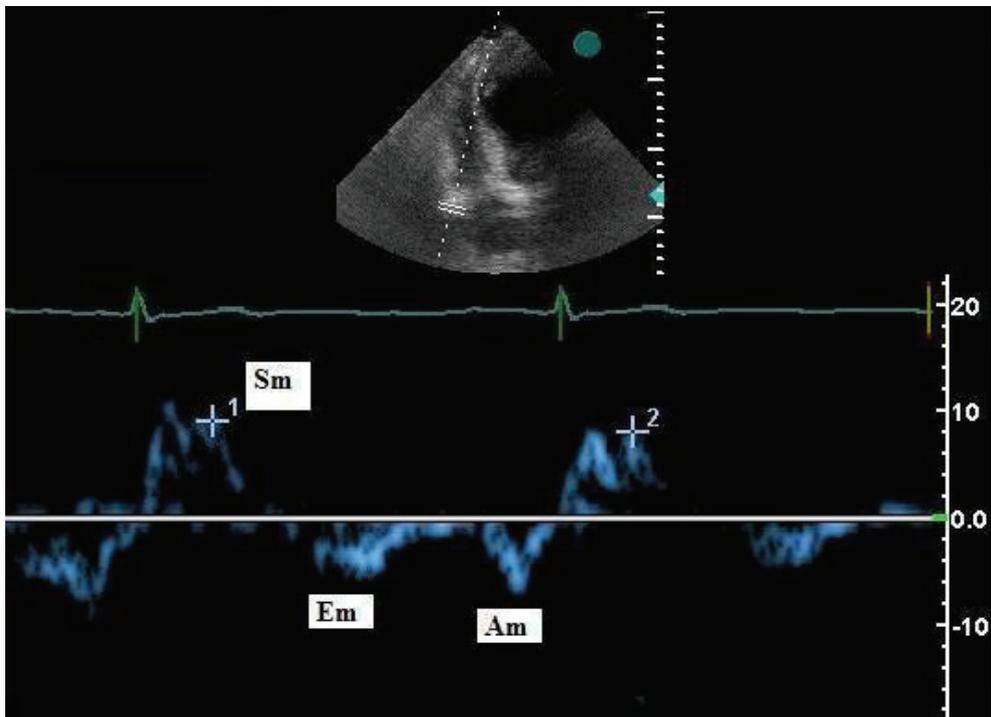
Pulsed-wave tissue Doppler imaging (TDI) velocities of tricuspid valve in a patient with pulmonary hypertension and severe RV failure.
